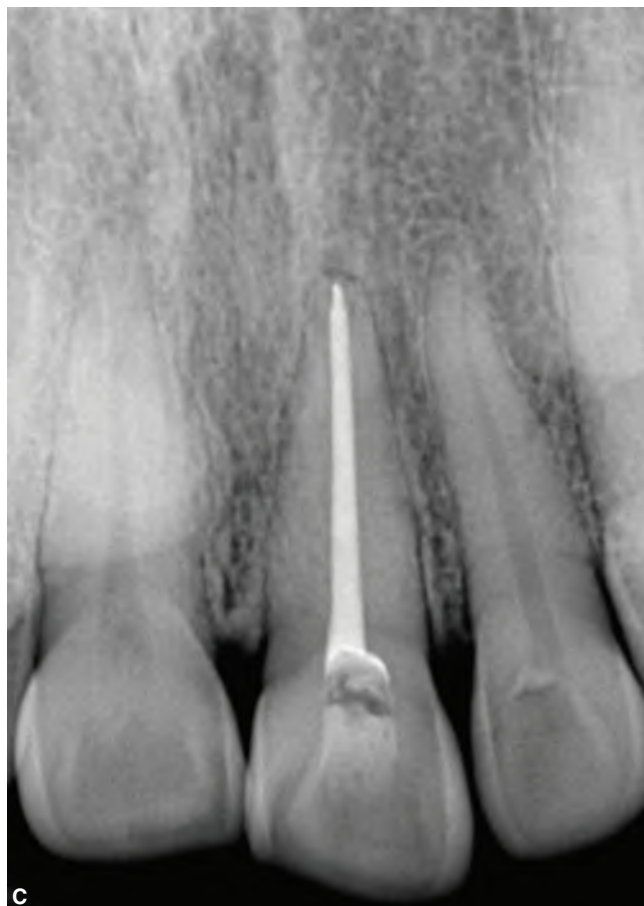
Patient with etiology of silent trauma. A. Radiograph of a symptomatic non-vital maxillary left central incisor in a 71-year-old female. The pulp space appears obliterated. Initially, the patient did not report of any history of traumatic injury to the tooth. After further inquiry, the patient recalled that she underwent surgery under general anesthesia 2 years previously. B. Cone Beam Computed Tomography (CBCT) views (coronal, axial, and sagittal) showing presence of patent root canal. C. Postoperative radiograph. The root canal system was prepared and obturated. Following treatment, the patient was asymptomatic.
